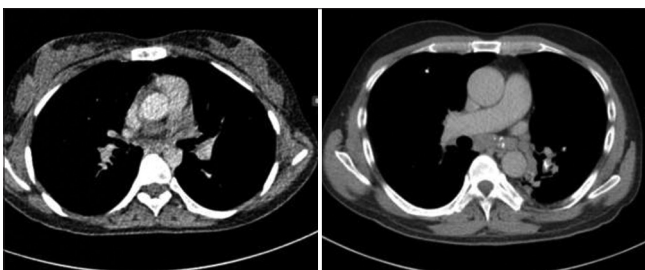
CT chest showing presence of necrotic mediastinal lymph nodes
